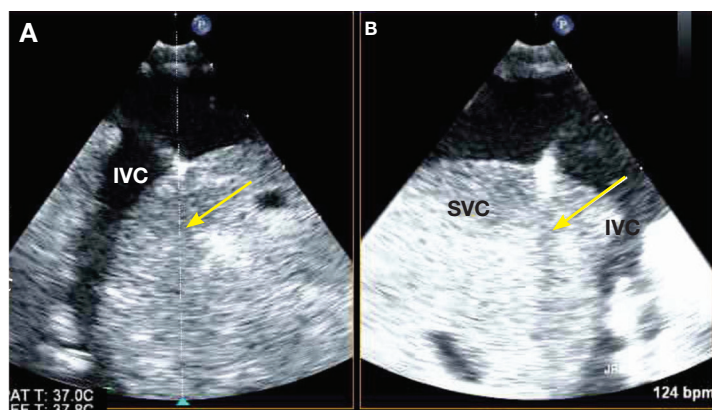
A) Transesophageal-guided biopsy of the mass in right atrium. (B) X-plane image of the right atrium mass during the biopsy by bioprobe (white arrow).
